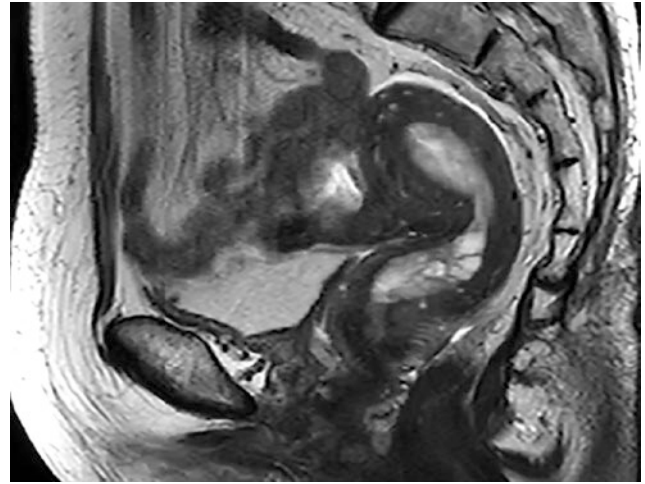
Sagittal T1-weighted contrast-enhanced image showed the endometrial hyperplasia
